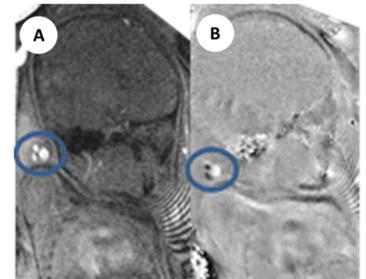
Magnitude (A) and the phase image (B) obtained from the phase contrast MRI. Note the different phase in the artery (dark in B) and the vein (bright in B).
